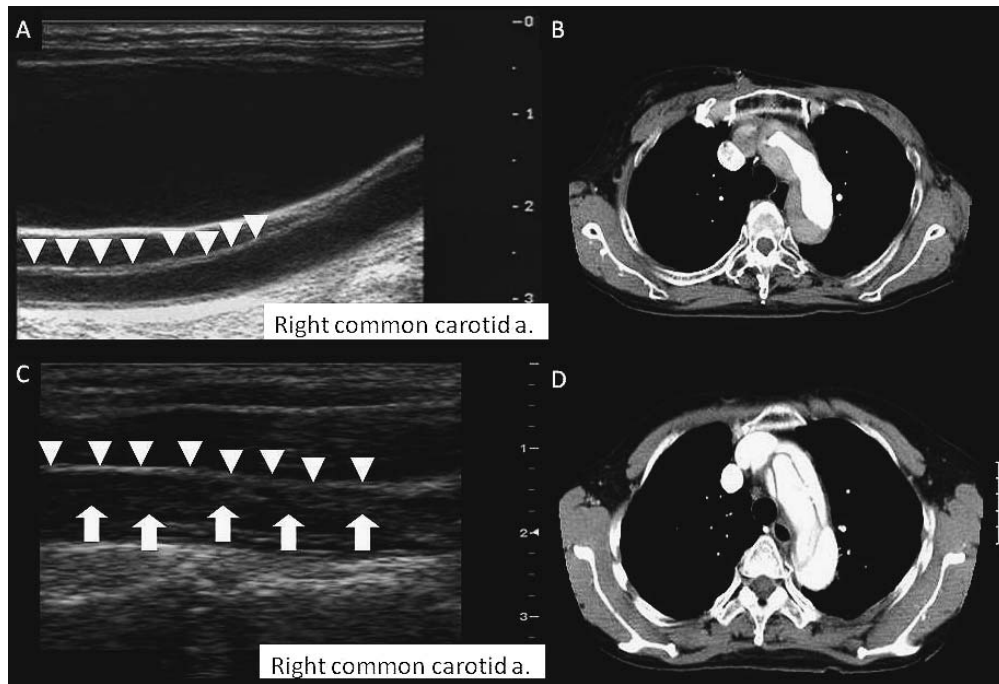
Case 1; (A) Carotid duplex ultrasonography of the transverse plane shows an intimal flap (white arrowhead) in the visible segment of the right common carotid artery. (B) Chest CT detected type A thoracic aortic dissection. Case 2; (C) Carotid duplex ultrasonography of the transverse plane shows an intimal flap (white arrowhead) and far wall of true lumen (white arrow) in the visible segment of the right common carotid artery. (D) Chest CT revealed type A thoracic aortic dissection.
